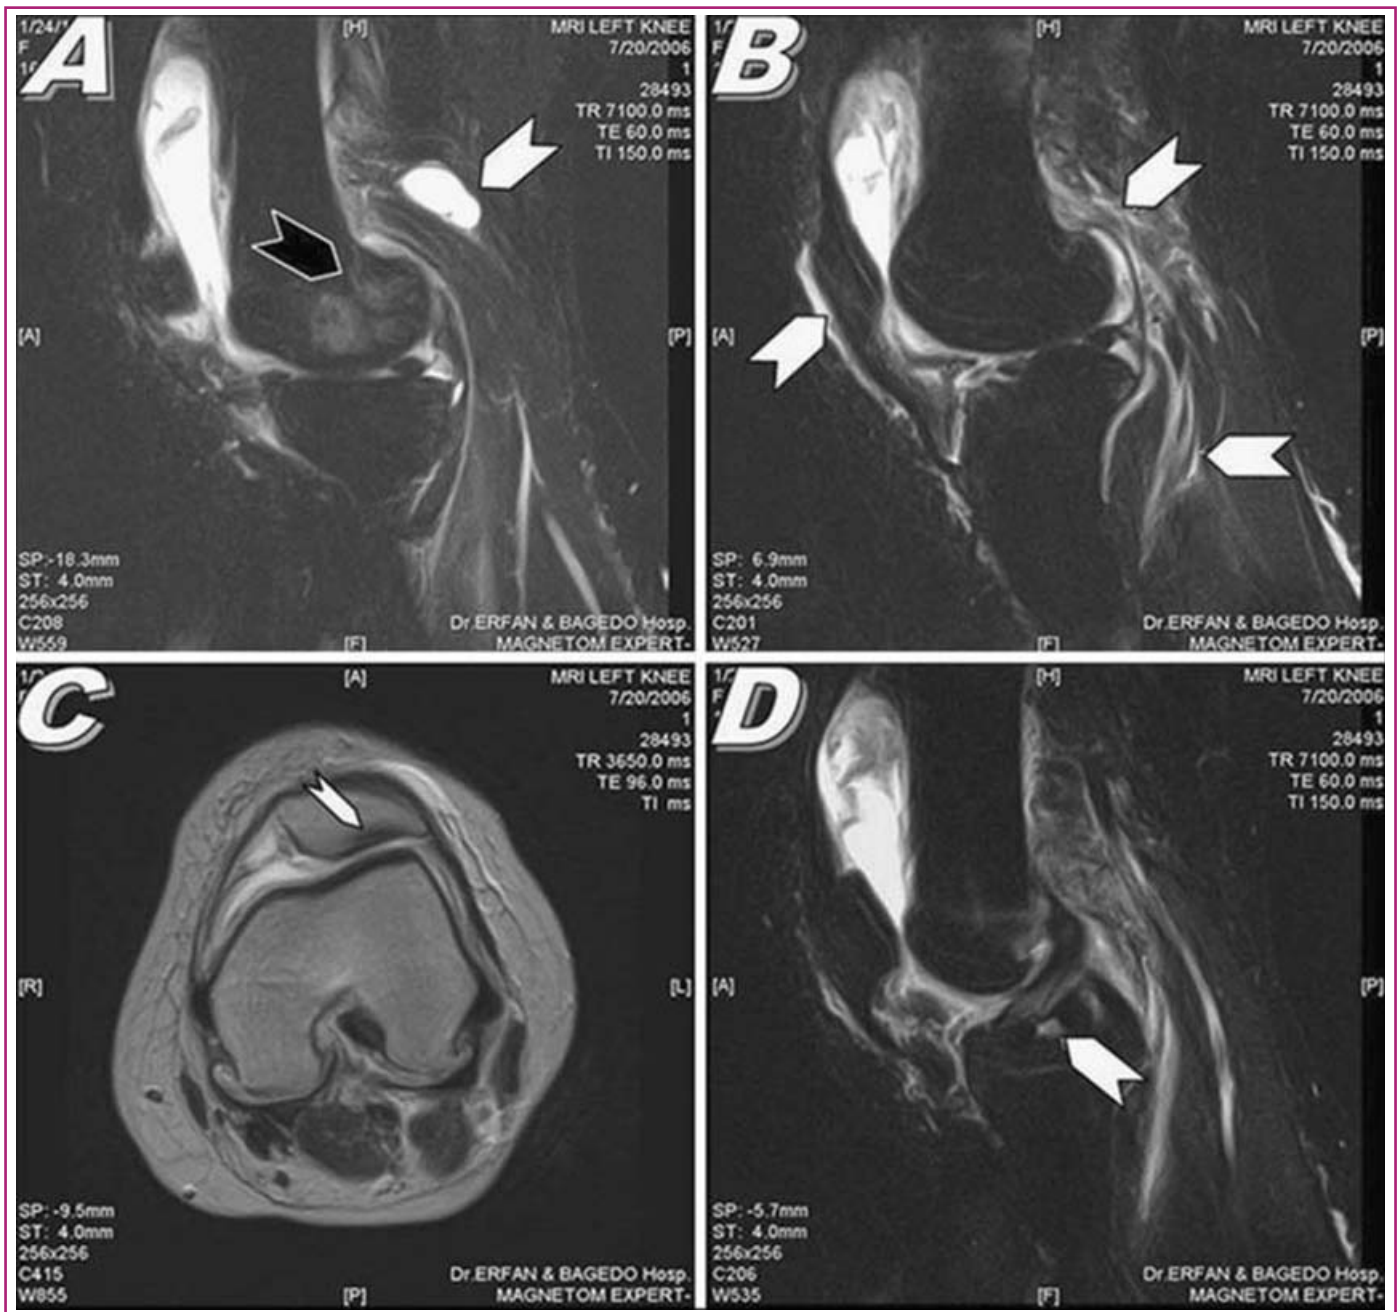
(a) Sagittal STIR sequence showing Backer's cyst (white arrow) and bone marrow edema of the femoral condyle (black arrow). (b) Sagittal STIR sequence showing periarticular soft tissue edema (white arrows). (c) Axial T2-weighted image showing denudation of the patellar articular cartilage (white arrow). (d) Sagittal STIR sequence demonstrating subcortical focal bony erosions (white arrow)
